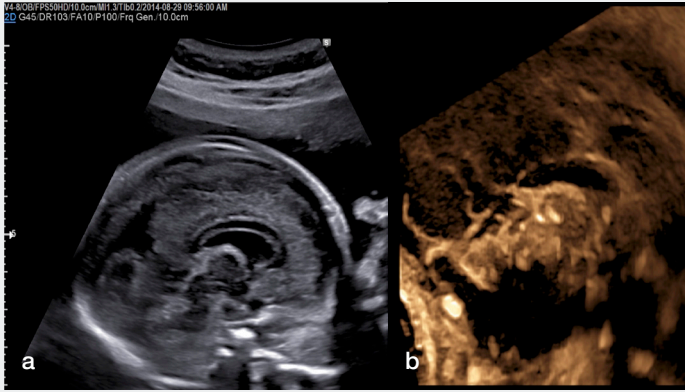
Ultrasound images showing corpus callosum and cavum septi pellucidi obtained in the same fetus by 2D ultrasound (a) and 3D ultrasound (b).
